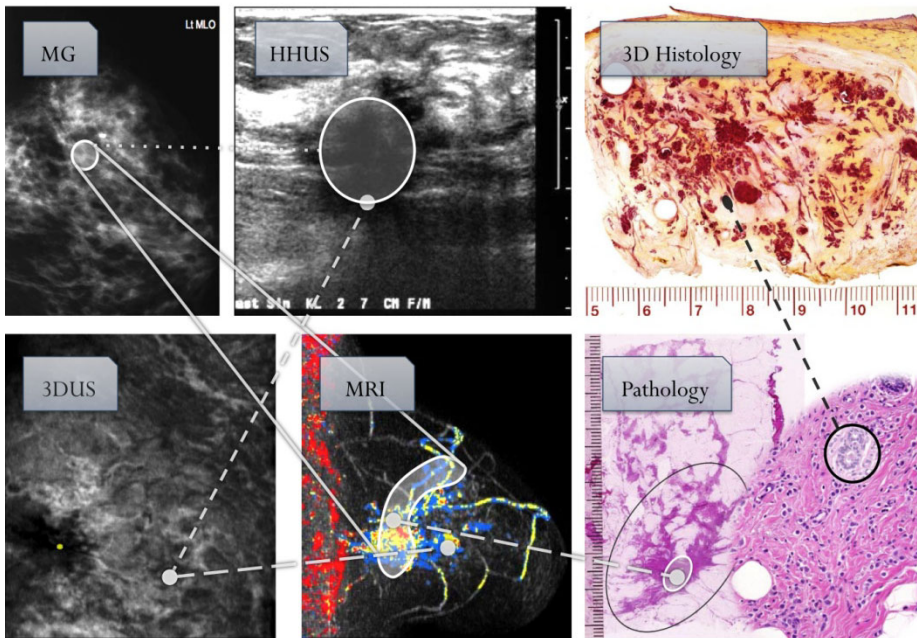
Advanced spatial referencing: Computations can provide estimations of corresponding locations or search regions, wherever features suffice for the task. From mammography (MG), referencing to MRI can be deduced from combinations of CC and MLO views. Volume ultrasound (3DUS) can be mapped to MRI in a local loose coupling fashion. Solid connections indicate computer-provided spatial referencing; dashed connections indicate interactively established correlations.
